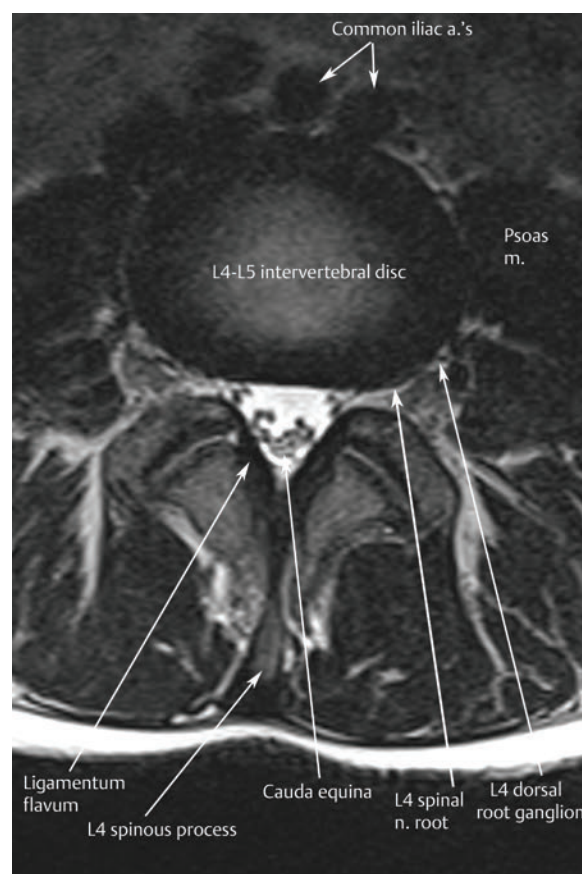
An axial T2-weighted image of the lumbar spine at the L4-L5 level shows the cauda equina, L4 spinal nerve root, and L4 dorsal nerve root ganglion. Normal flow voids are seen within the common iliac arteries, just below the aortic bifurcation.[†]
